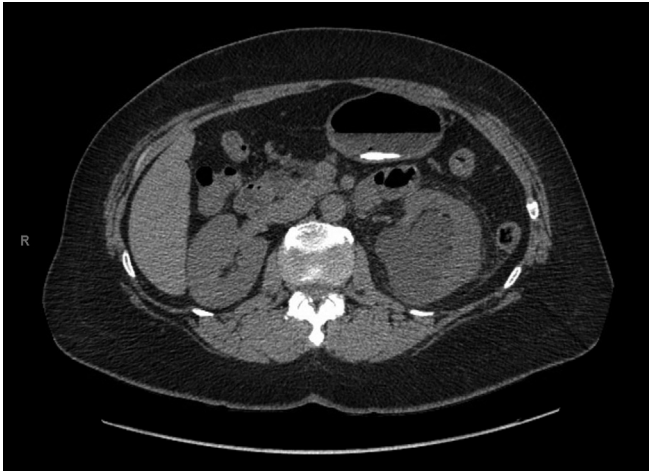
CT without contrast demonstrating a UPJO and hydronephrosis of left kidney.
